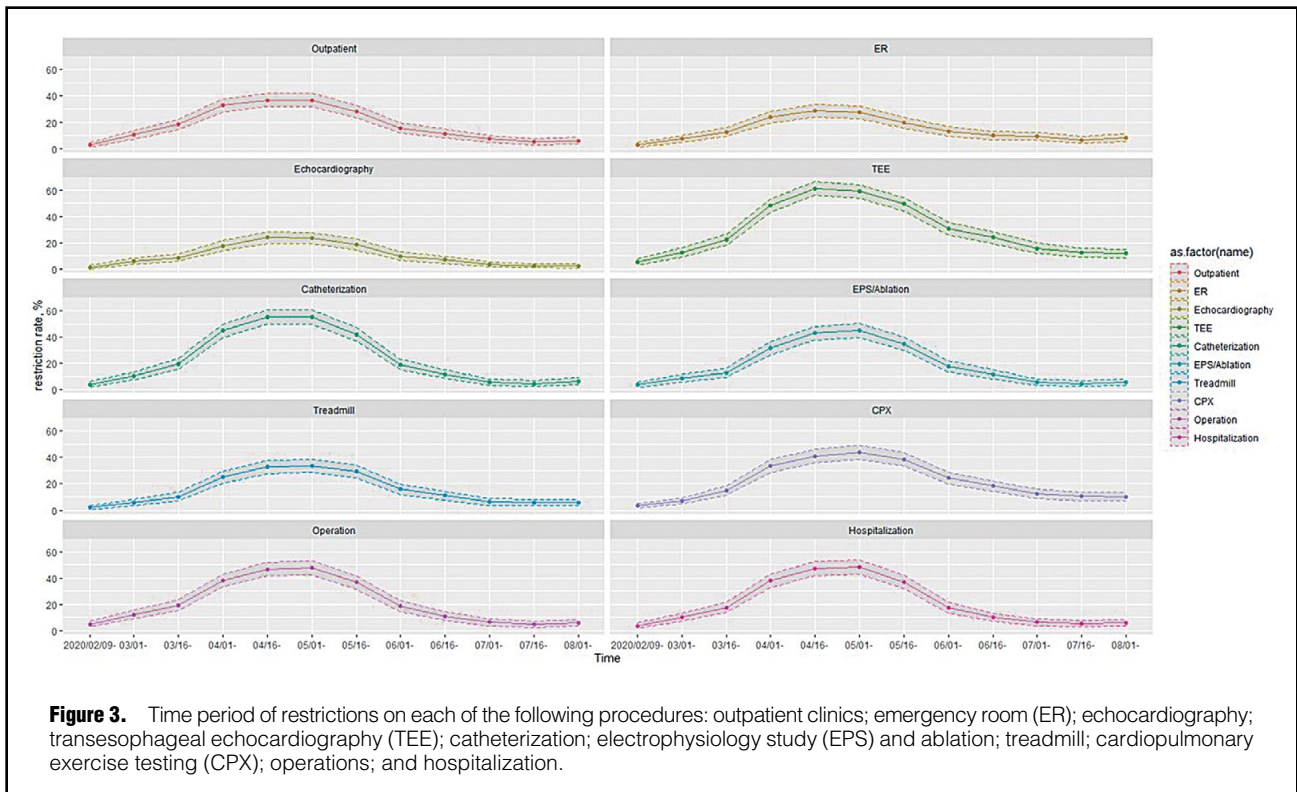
Time period of restrictions on each of the following procedures: outpatient clinics; emergency room (ER); echocardiography; transesophageal echocardiography (TEE); catheterization; electrophysiology study (EPS) and ablation; treadmill; cardiopulmonary exercise testing (CPX); operations; and hospitalization.
